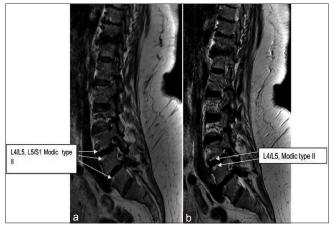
Disc degeneration, Modic change type II, disc protrusion and exit nerve compression in a 68 years old female reffered for Lumbar magnetic resonance imaging at BSCB Medical College. (a) Sagittal T1 weighted (T1W): Showing endplate bright signal at L4/L5 and upper anterior endplate of S1. (b) Sagittal T1W: Multilevel disc degeneration are seen (low signal of discs signifyingdessication), bright signals at endplates of L4/L5 and upper endplate of S1
